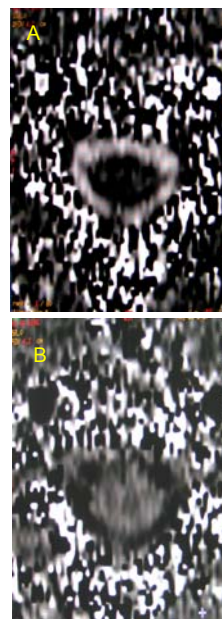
Cerebrospinal fluid flow in the vertebral canal on phase-contrast cine MRI.
